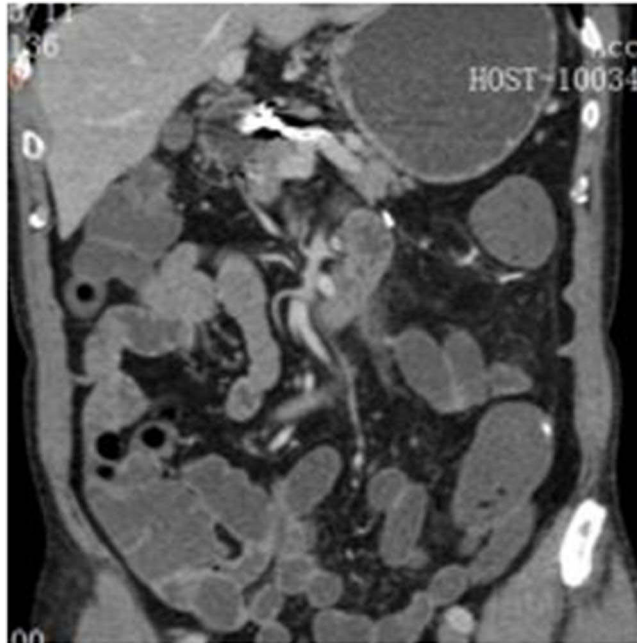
Reexamination based on an abdominal computed tomography scan showed postoperative changes in the proximal branch aneurysms of the common hepatic artery.
